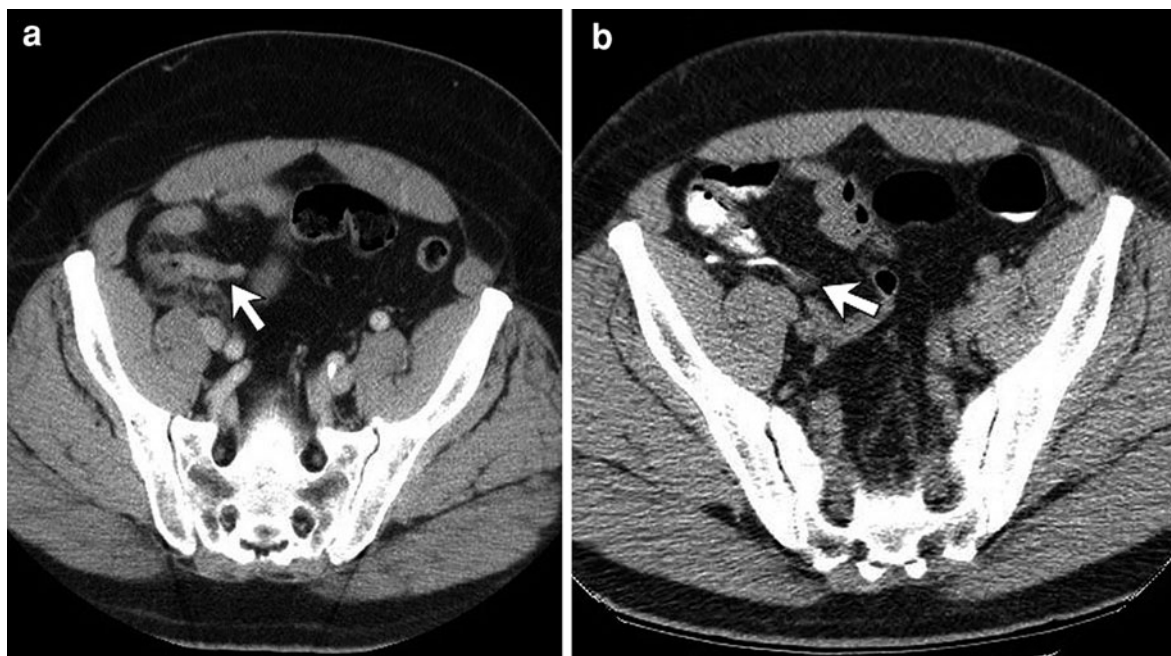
Signet ring adenocarcinoma of the appendix presenting with acute appendicitis. Contrast-enhanced axial CT image (a) shows diffusely thickened appendix (arrow) with periappendiceal soft-tissue infiltration. At laparoscopic appendectomy and subsequent right hemicolectomy, a primary appendiceal
